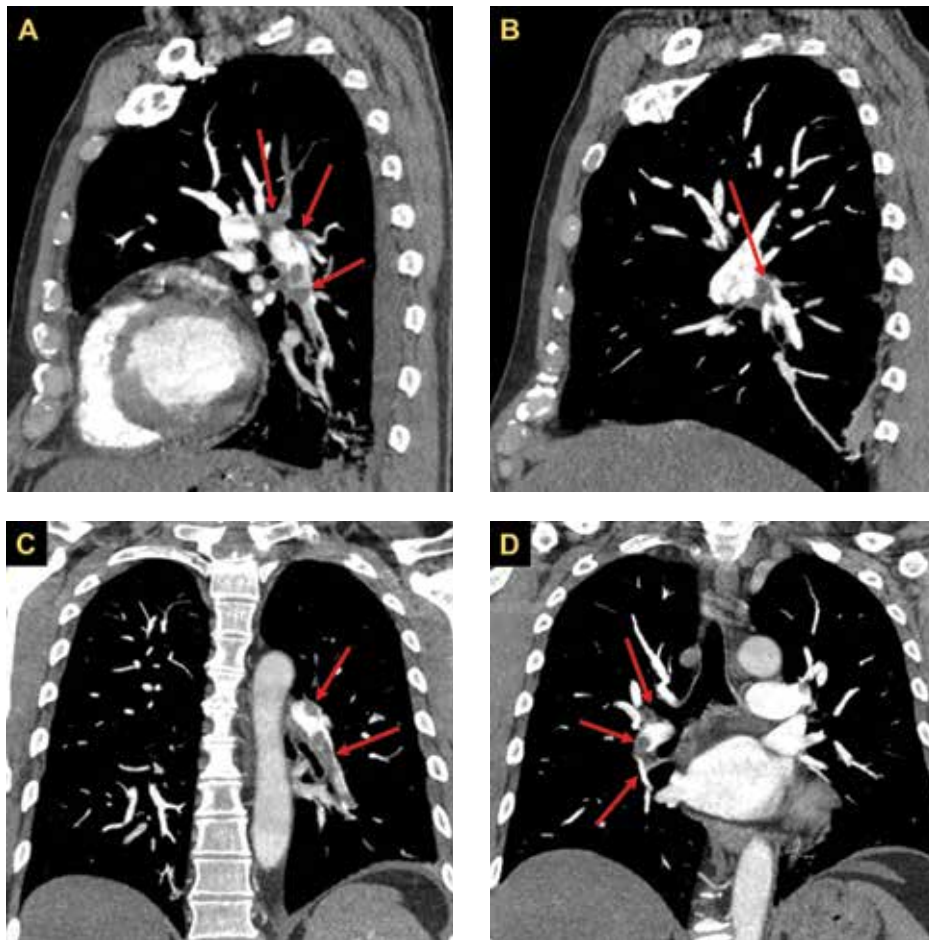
Computed tomography pulmonary angiogram images of bilateral pulmonary emboli, with areas of thrombi indicated by red arrows. A: Pulmonary artery (PA) thrombi in the left lung, seen in sagittal plane. B: PA thrombi in the right lung, seen in sagittal plane. C: PA thrombi in the left lung, seen in coronal plane. D: PA thrombi in the right lung, seen in coronal plane.
